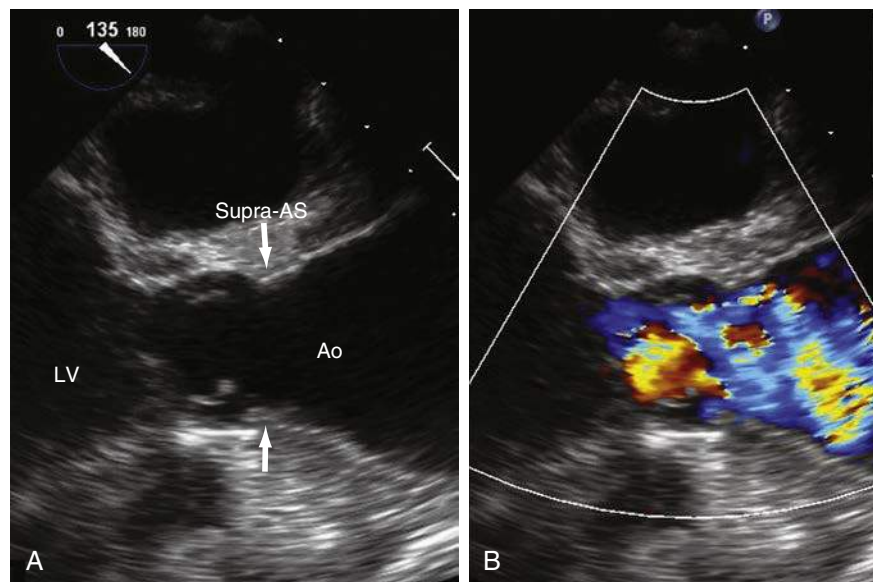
A, Two-dimensional transesophageal echocardiogram left ventricular outflow tract (2D TEE LVOT) view showing supra-aortic stenosis (*white arrow*). B, Color Doppler shows turbulent flow at the level of the supra-aortic valve. *Ao*, aorta; *LV*, left ventricle.
